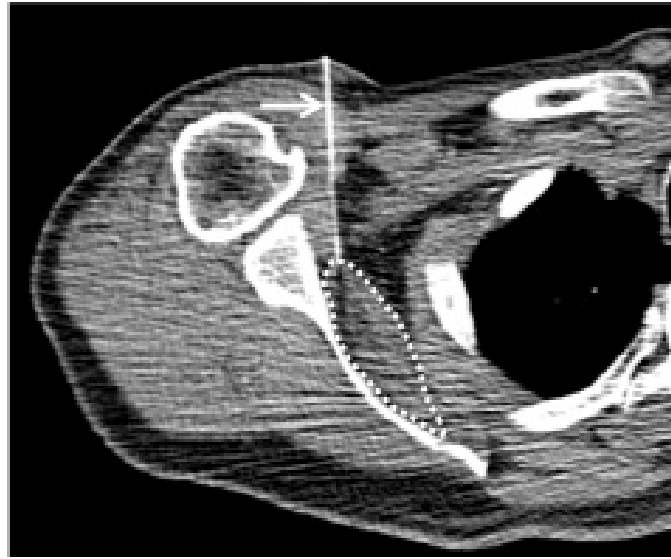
Computed tomography (CT) image-guided botulinum injection highlighting a case of a male tetraplegic patient who was experiencing disabling spasms in his upper limb. Axial CT image of the patient lying supine. A 25-gauge needle (*white arrow*) was placed into the subscapularis muscle (*dashed lines*) via an anterior approach. The patient's spasms subsided for 3 months following the injection.
